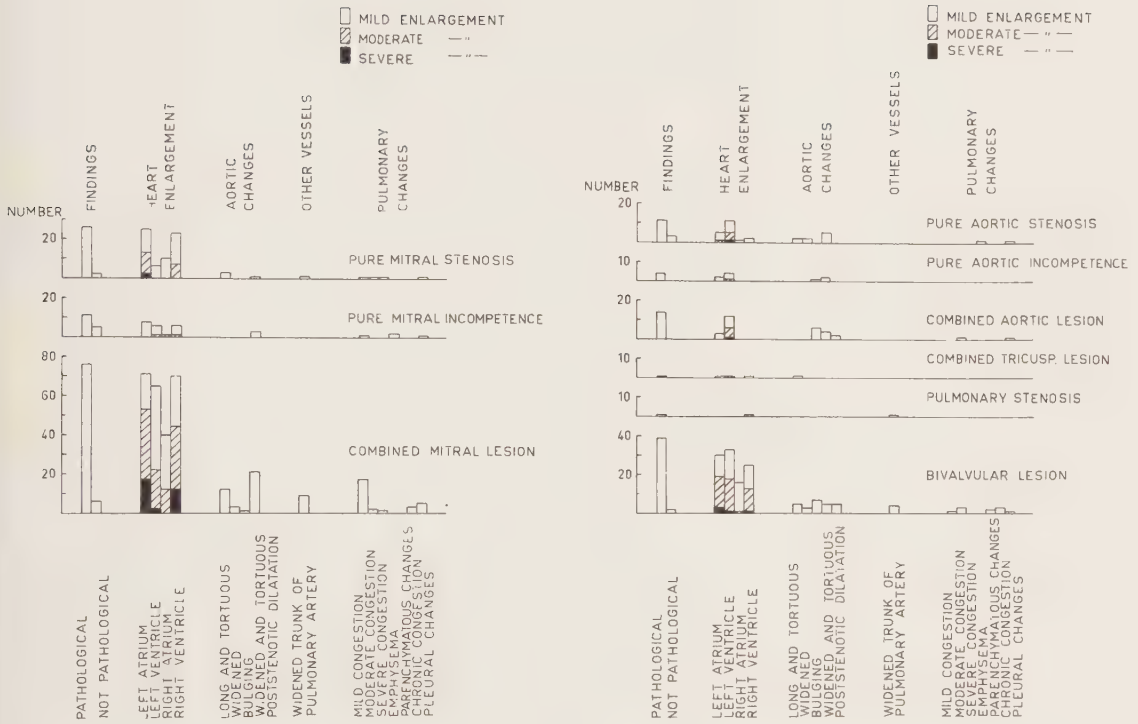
Roentgenological findings in patients with rheumatic heart disease.
